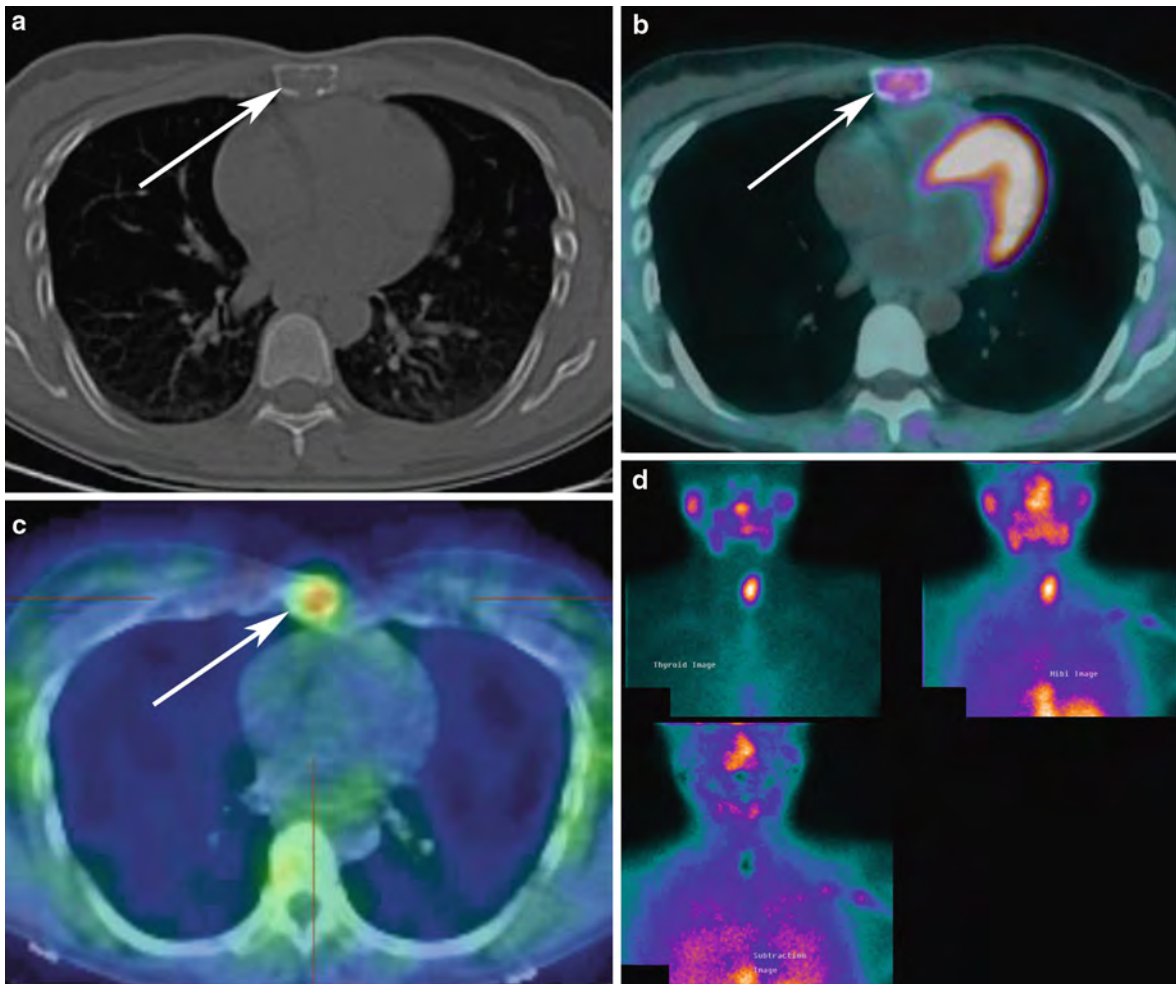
Sternal metastasis from parathyroid carcinoma demonstrated on axial CT (a), ^{18}F -FDG-PET (b) and octreotide scintigraphy (c) (arrows) but not apparent on $^{99\text{m}}\text{Tc}$ -sestamibi (d)
